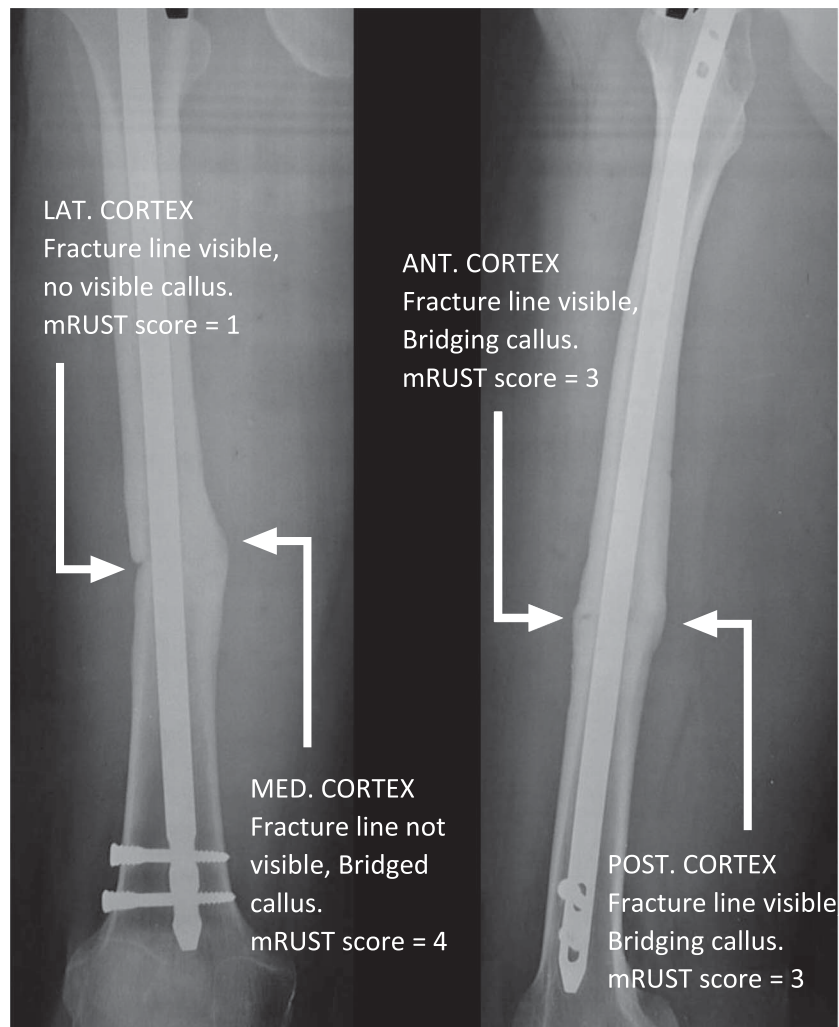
mRUST scoring breakdown. Anteroposterior (Left) and lateral (Right) radiographs of femur with SIGN IMN detailing mRUST scoring breakdown. Arrows and text refer to different stages of callus formation and their subsequent mRUST score.
